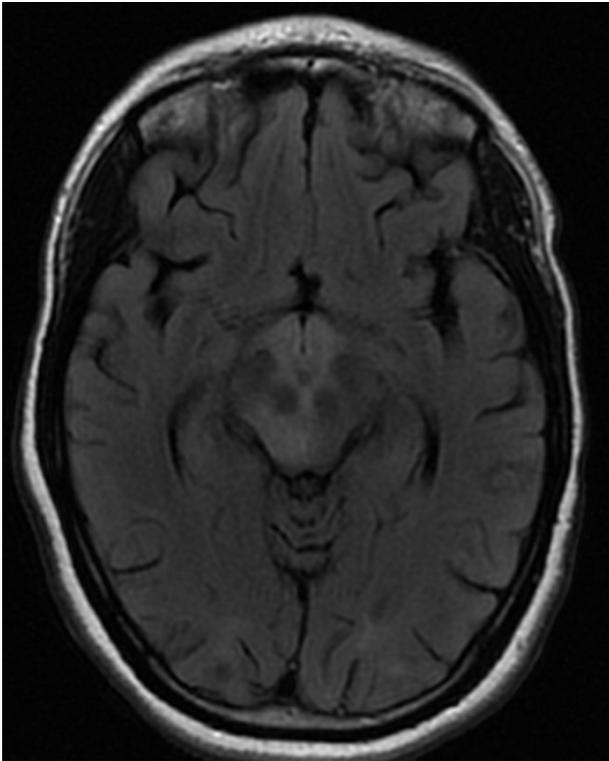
T2/FLAIR hyperintense signals within the right midbrain, hypothalamus, and subcortical bilateral occipital lobes.
